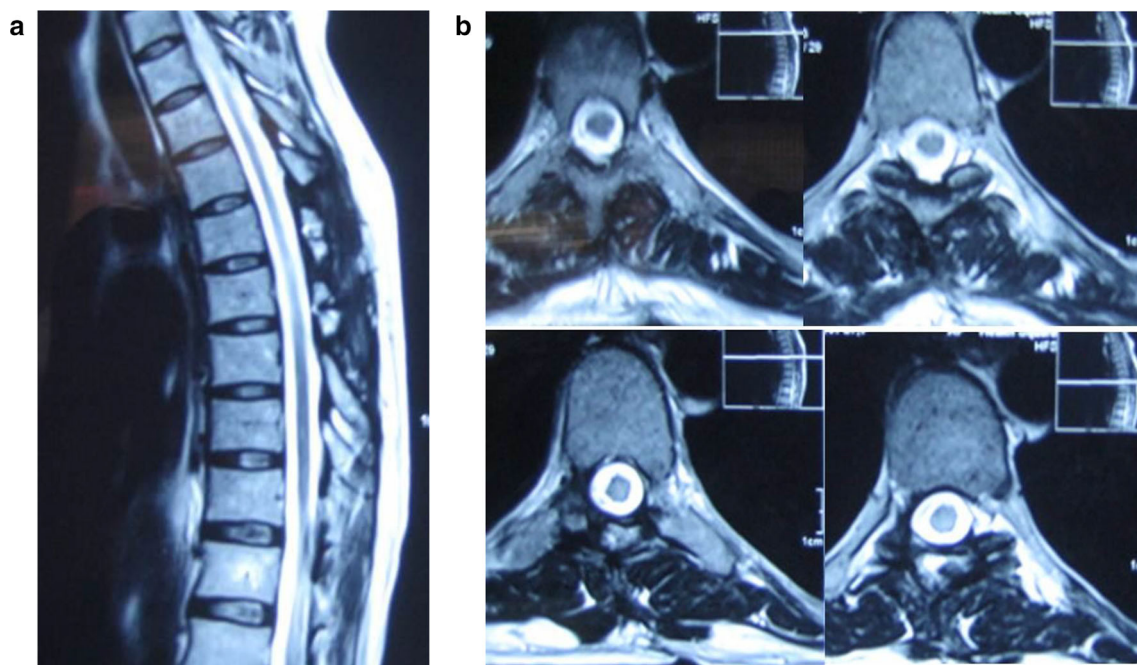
a Post-operative midsagittal T2WI MRI image of the same patient showing complete excision of tumor. b Post-operative axial T2WI MRI image at D7–9 level of the same patient showing complete excision of tumor
